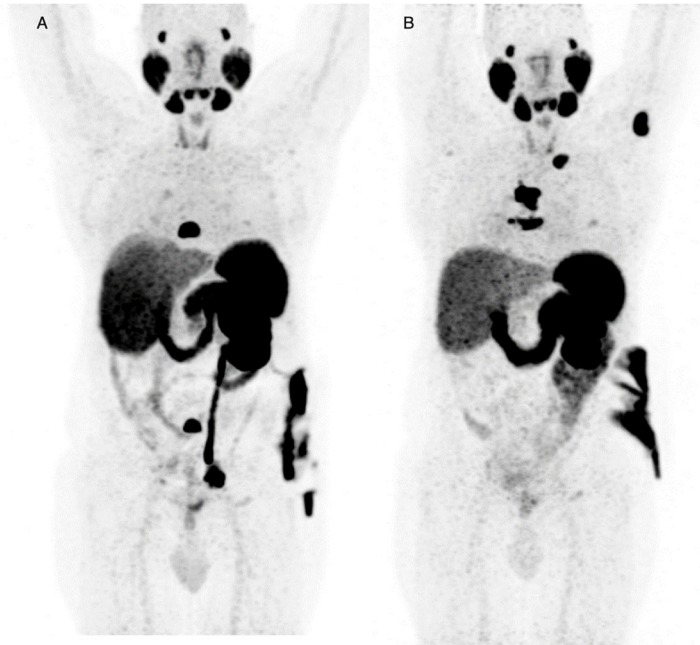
PPP for appearance of more than 2 new distant lesions, with other lesion disappearing. 63 years old male with history of previous nephrectomy due to clear cell renal cell carcinoma; in 2011 radical prostatectomy (pT3bpN0 Mx, Gleason Score 4+5, iPSA=11 ng/mL), plus adjuvant EBRT; in 2016 biochemical recurrence, treated with ADT, castration resistance in 2018, with evidence of PSMA positive bone lesions at dorsal and lumbar spine (A). After EBRT to these lesions, almost complete disappearance of the previously evident lesions, but appearance of other new lesions (B). As more than 2 new PSMA positive lesions progression according to PPP.
